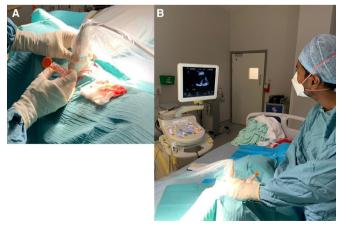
Real-time free-hand technique demonstrated with dominant hand controlling the cutting needle (A). Operator should be positioned facing the ultrasound machine with patient in lateral decubitus position in between (B).
